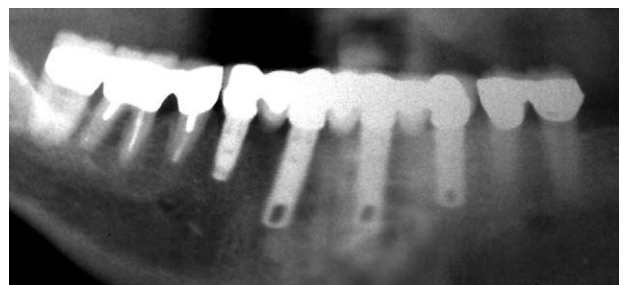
The postoperative, panoramic radiograph revealing successful implant placement which supported a 6 unit ceramometal restoration.
